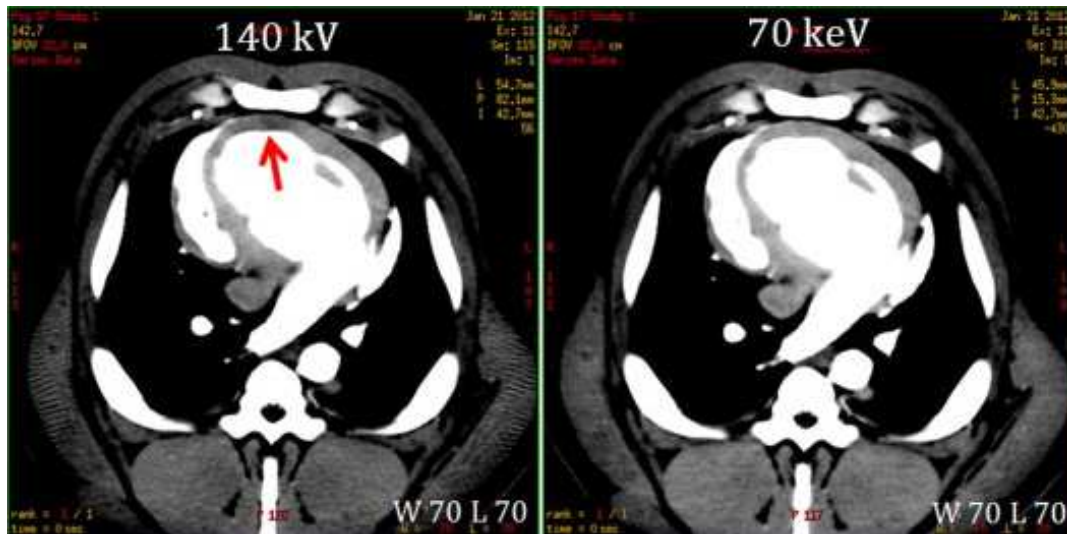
Visualisation of slices from two energy volumes (140 and 70 keV) of a dual-energy CT dataset. The area where the difference is most obvious is marked with an arrow. Figure from: A. So. Dual-energy CT and its potential use for quantitative myocardial CT perfusion. *Journal of cardiovascular computed tomography*, 2012, 6, 308-317. Used with permission from Elsevier B.V.
